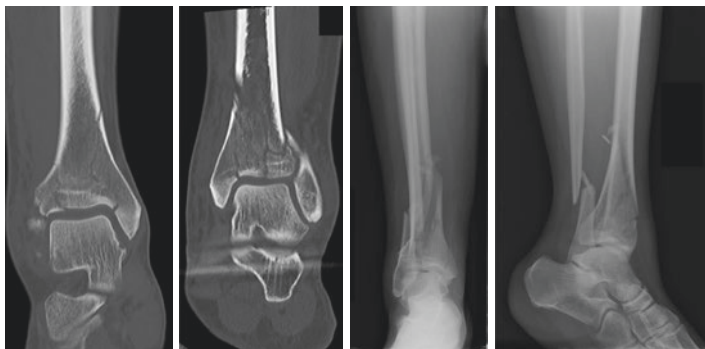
Representative CT and radiographic images of Pilon fractures
